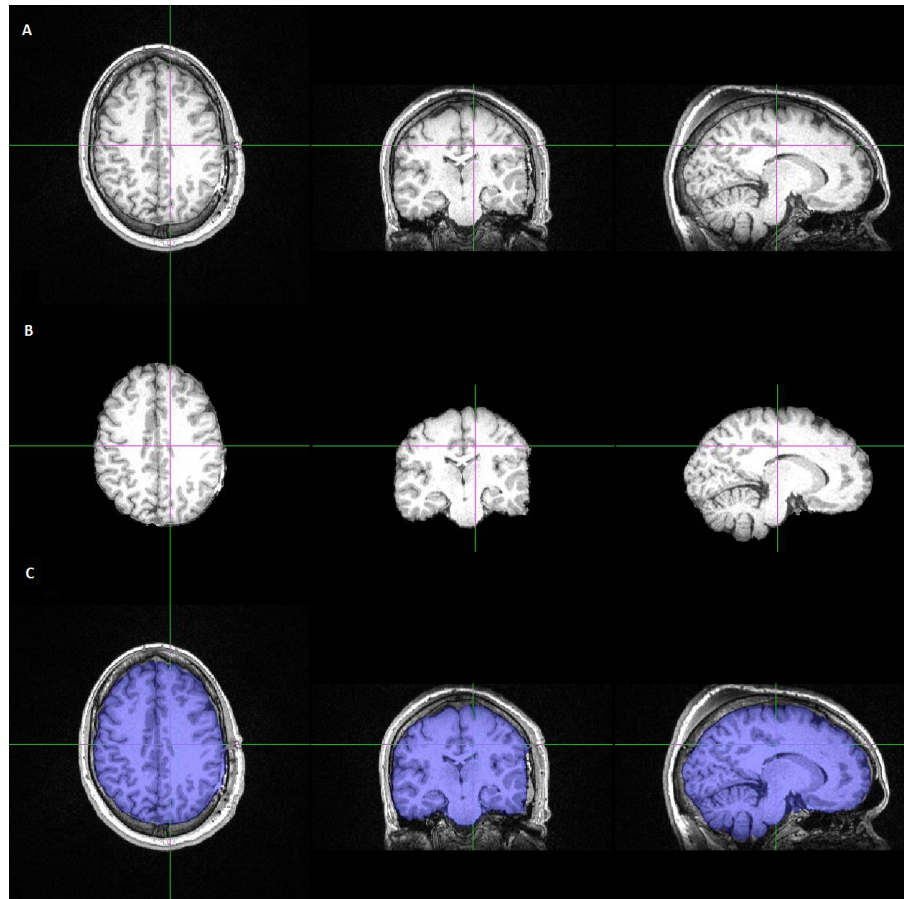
A - Post-operative T1-MRI; B - T1-MRI after skull stripping using BET and C - Fusion of the images in A and B, where the extracted brain is displayed in blue
